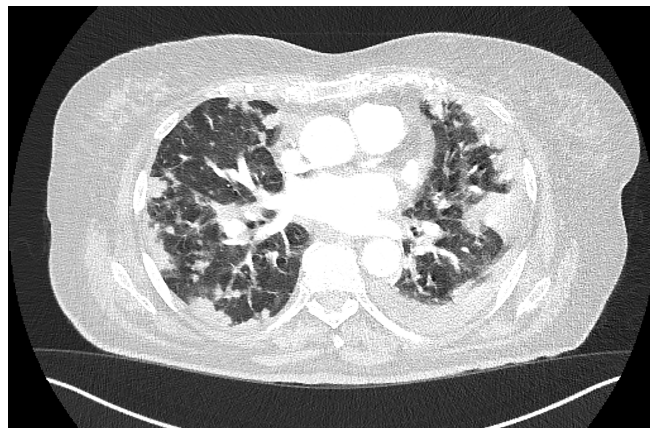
Initial thoracic CT scan (lung window). Multiple bilateral opacities and left pleural effusion.
